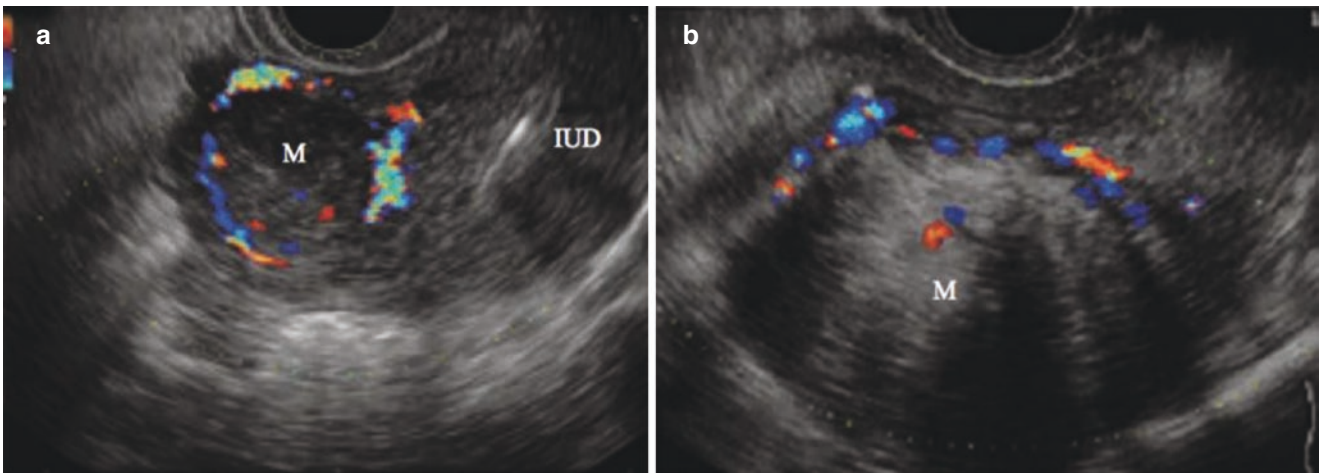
Leiomyoma (VIII). (a, b) The image of circular or semicircular flow around the fibroid shown by color Doppler
